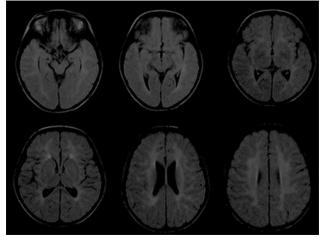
FLAIR axial images of MRI brain shows mild diffuse cerebral and cerebellar atrophy with prominence of ventricular system and diffuse white matter hyperintensities in periventricular and subcortical regions
